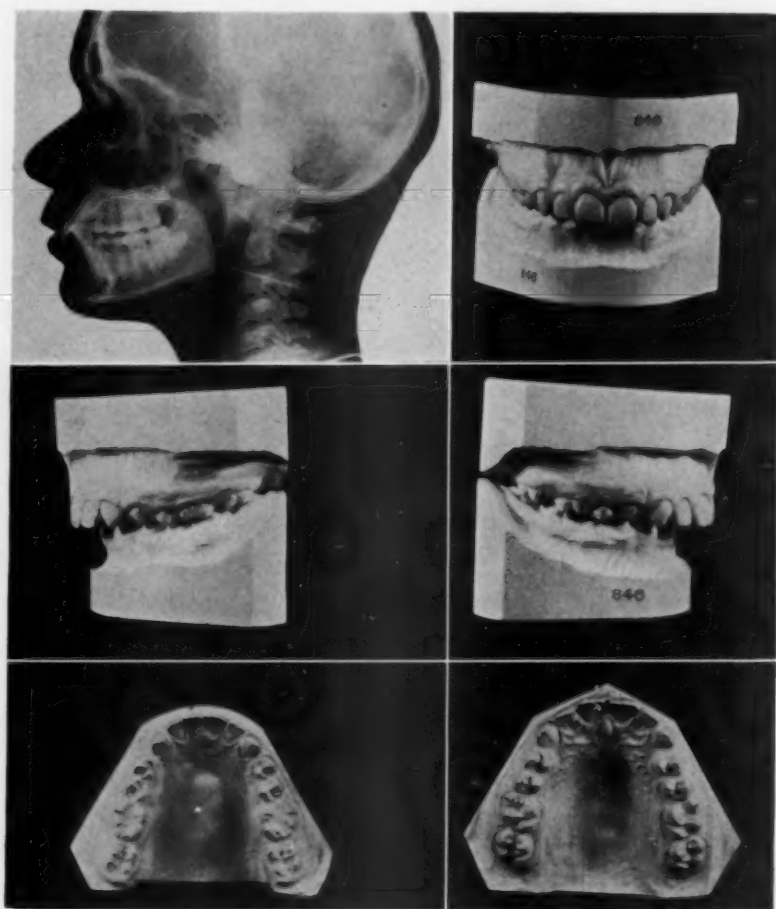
Headplate x-ray and models of a Type B, subdivision I case.
